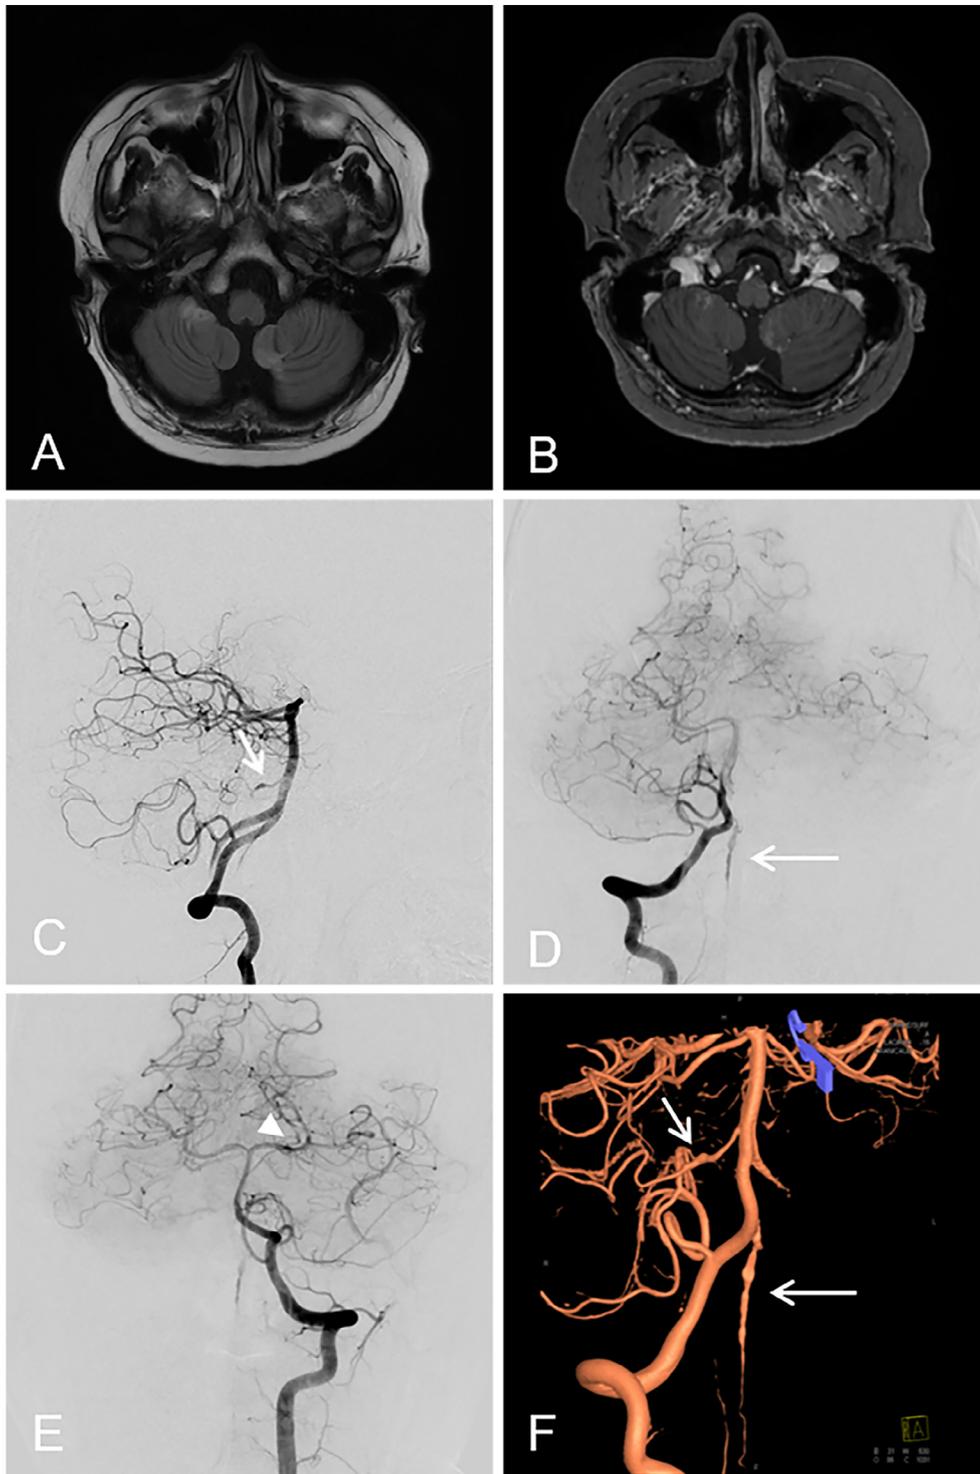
MRI and catheter angiography performed for evaluation of recurrent neurological symptom in the course of treatment. Brain MRI performed due to a sustained headache showed new T2/FLAIR hyperintensity in the bilateral inferior cerebellum (A, B) and the right lateral medulla (now shown in this image) with irregular enhancement. Catheter angiograms (C, D, E) and their three-dimensional reconstruction (F) revealed multifocal luminal ectasia in anterior spinal artery (long arrow), right anterior inferior cerebellar artery (short arrow) and left posterior cerebral artery (arrowhead).
